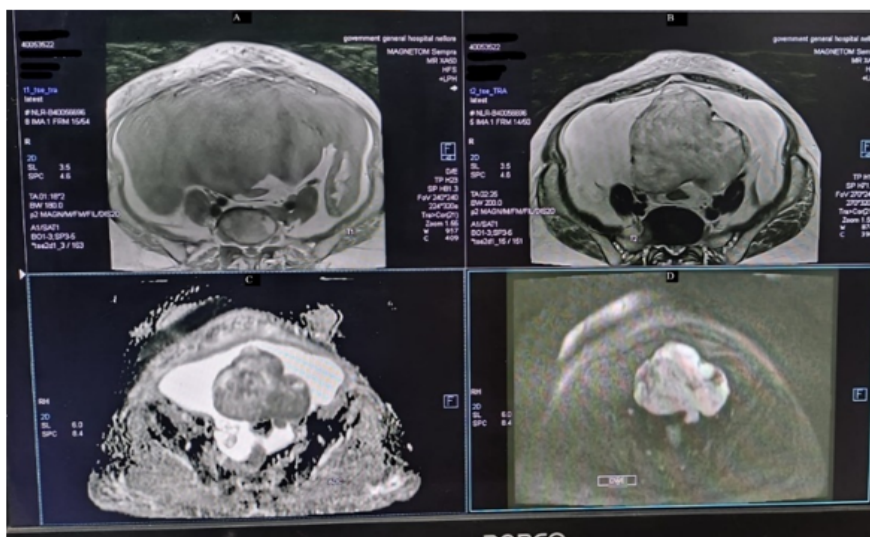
A: Axial T1 weighted image of MRI pelvis predominantly solid lobulated hypointense lesion with few intermediate signal intensity areas within. B. Axial T2 weighted image showing lobulated heterogeneously hyperintense lesion. C. ADC image showing hypointense signal in entire lesion. D. DWI image at b1000 showing true Restricted diffusion
